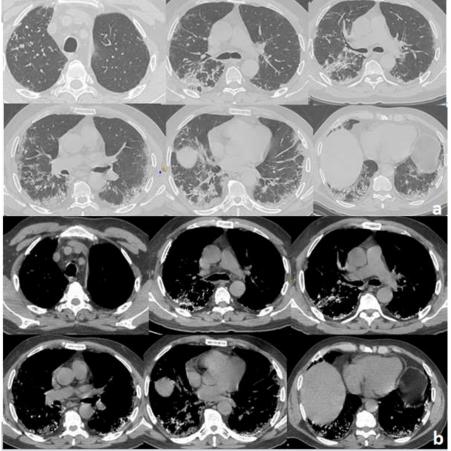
Axial thin-section unenhanced baseline CT scan(a) axial parenchymal window showed bilateral and patchy consolidation with a prominent peripherally subpleural distribution associated to reticulations in the lower lobes, (b) mediastinal window showing the calcifications within the pathologic area.
